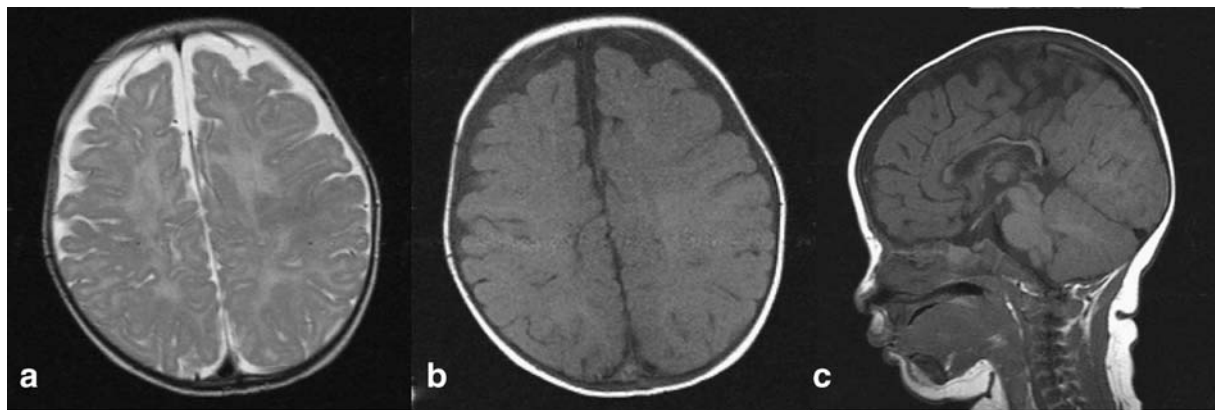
At 6 months of life, axial T2- and T1-weighted MR images demonstrated resolution of previously noted, multiple, dot-like lesions in the corona radiata of both cerebral hemispheres (a and b). The
